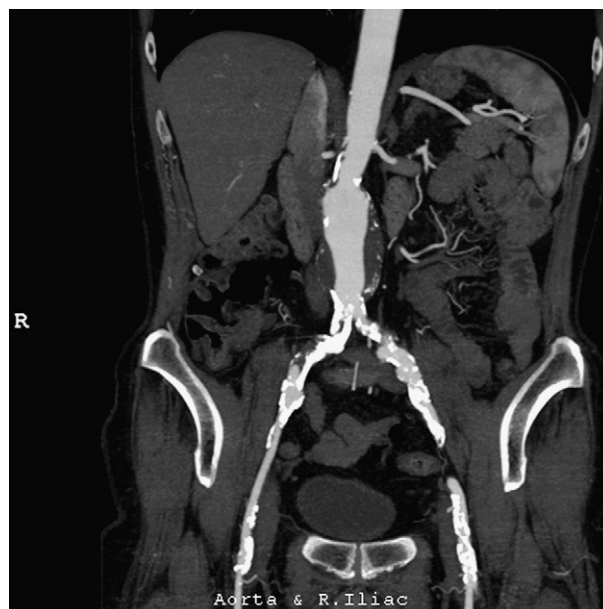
Coronal reconstructions from CT angiogram demonstrating right common iliac artery occlusion and severe left common iliac artery calcified stenoses.
